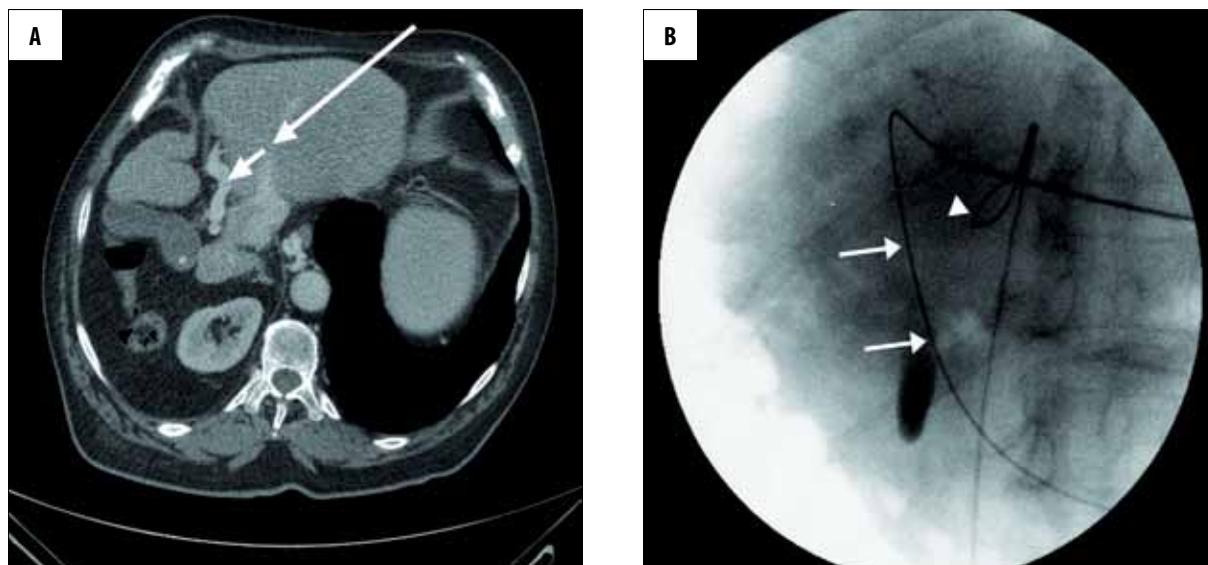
(A) Axial CT image shows the relation of the left hepatic vein (LHV) (long arrow) and the left portal vein (LPV) (short arrow) in one plane, which was used for percutaneous puncture (the percutaneous puncture tract is marked with white arrows). (B) X-ray image demonstrates transhepatic-portal guidewire snaring. A guidewire is advanced in the portal circulation (arrows) after simultaneous CT-guided puncture of the LPV through an open snare loop located in the LHV (arrow head).
